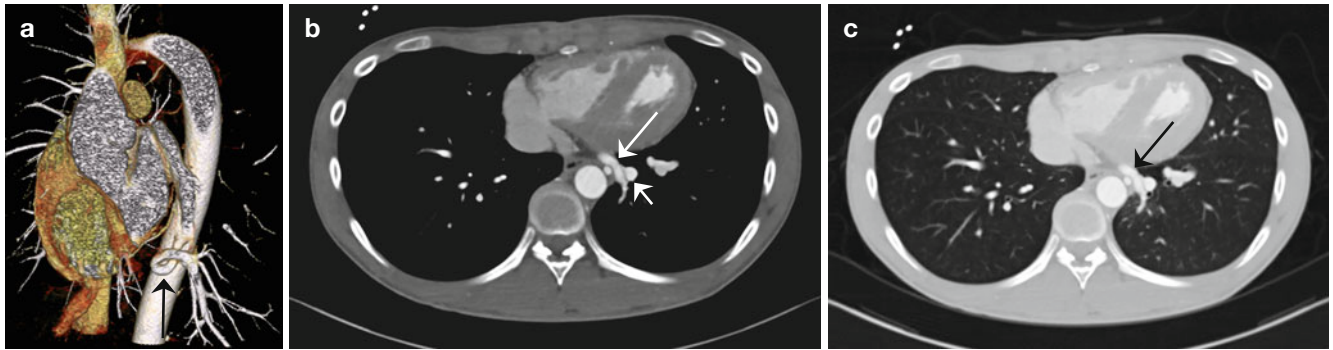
(a–c) Systemic arterial supply to normal lung. Volume-rendered CT image shows a systemic artery (*arrow*) arising from the descending thoracic aorta and supplying the left basal lung (a). Axial CT images with mediastinal (b) and lung (c) window settings reveal a
